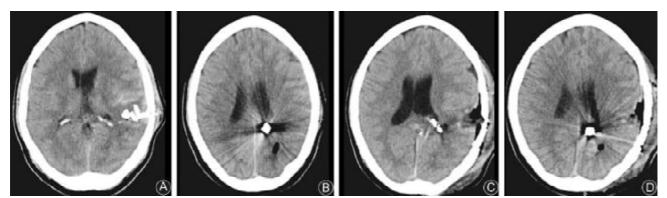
Axial CT scan of the brain after exposure to an implanted bomb blast, showing left parietal fracture, traumatic subarachnoid hemorrhage and secondary intraparenchymal bone fragments (A). Another axial view of the same patient showing nut-bolt seated close to lateral ventricle (B). Postoperative CT scans showing removal of superficial bone fragments, while deep seated fragments and shrapnel left behind (C and D).
